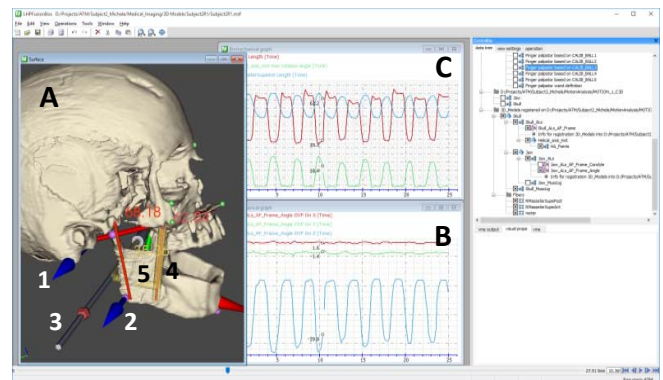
Example of results (displayed in lhpFusionBox). A: snapshot after fusion between AN_data and MO_data. B: motion representation (here OVP convention, other conventions are available as well). C: real time display of musculoskeletal value (indexed in A). 1 and 2: proximal and distal motion frames, respectively. 3: instantaneous helical axis. 4: MRI estimation of one masseter m. fiber. 5: direct moment arm of 4 (shorter distance with 3, visible through the jaw that was made transparent here).
